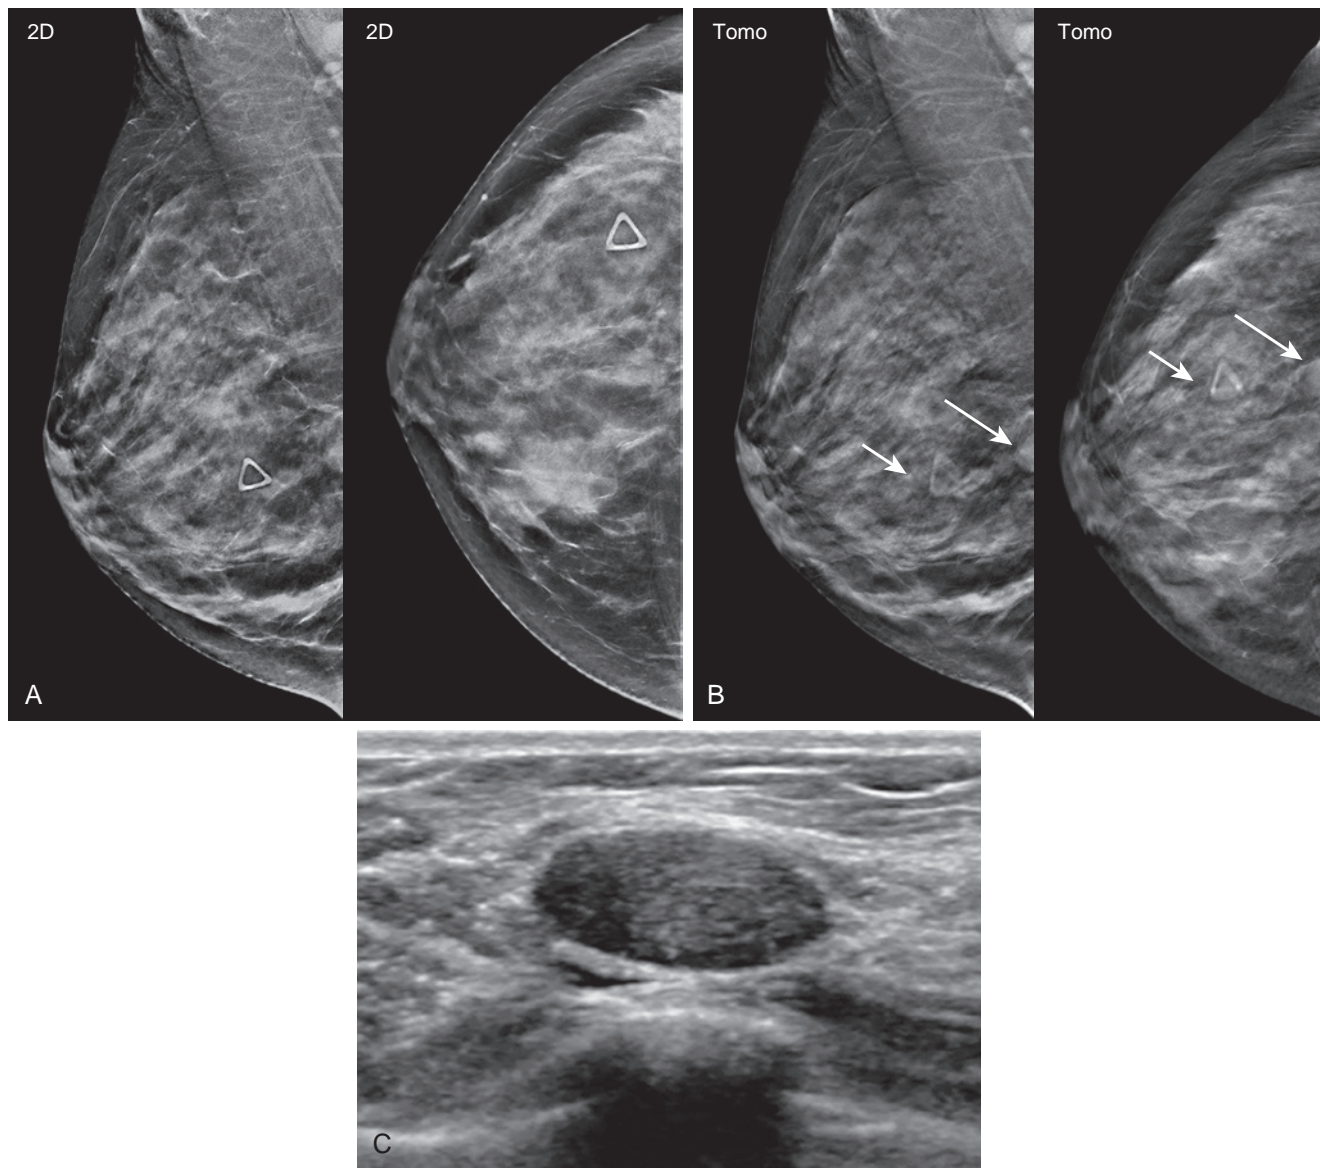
Palpable fibroadenoma seen on tomosynthesis and ultrasound. (A) A 34-year-old woman presents with palpable mass in the right breast, denoted by a triangular radiopaque skin marker. Two-dimensional mediolateral oblique and craniocaudal views reveal dense breast tissue and no suspicious findings. (B) Tomosynthesis views demonstrate suggestion of partially visualized mass (*long arrows*) located posteriorly to skin marker (*short arrows*). (C) Ultrasound reveals an oval circumscribed hypoechoic mass, likely representing a fibroadenoma, corresponding to the palpable abnormality, BI-RADS 3, stable on follow-up.
